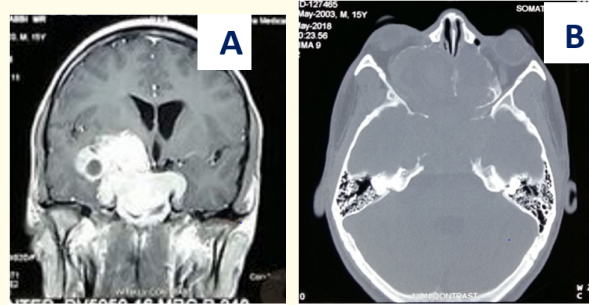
(A) MRI of brain coronal section showing contrast enhancing lobulated mass in suprasellar, right parasellar extending to sylvian fissure, right thalamus compressing the third ventricle as well. (B) CT scan bone window view: Expansile lytic lesion causing thinning of medial wall of both orbit.
